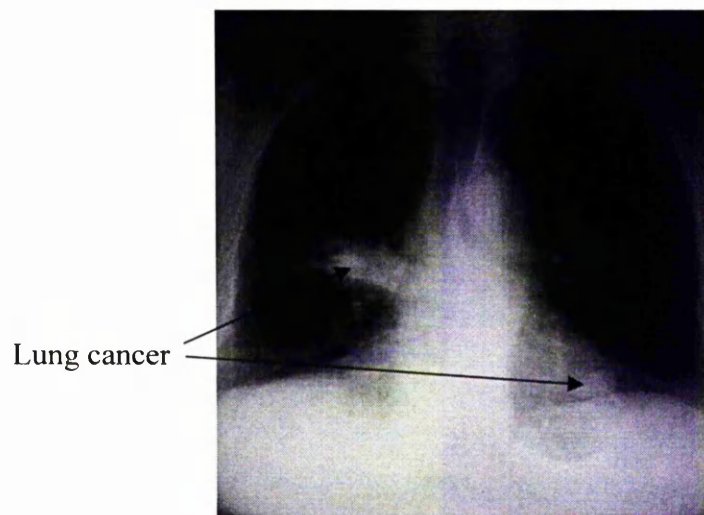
The chest x-ray appearance of a primary lung carcinoma.
